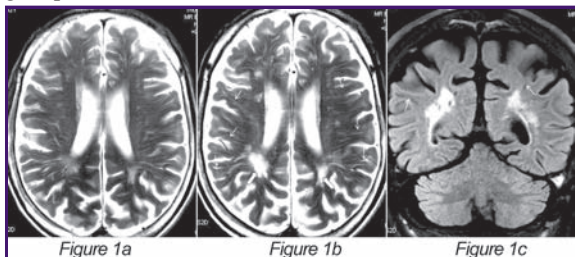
Axial T2 weighted images of the same octogenarian taken 5 years apart showed obvious progression of the white matter hyperintensities (WMHs) in both the deep and periventricular white matter. The confluent periventricular WMHs are also more obvious in the parietal lobes (open arrow). These WMHs are well depicted on the coronal FLAIR images (figure 1c). Please note that the age-related prominent perivascular spaces (arrows on figure 1b) are confirmed to be CSF-filled linear structures on the FLAIR study (arrow on figure 1c) with no hyperintense signals.
